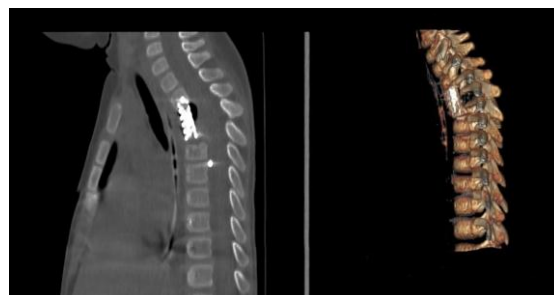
CT images and 3D reconstruction of the spine after surgery
